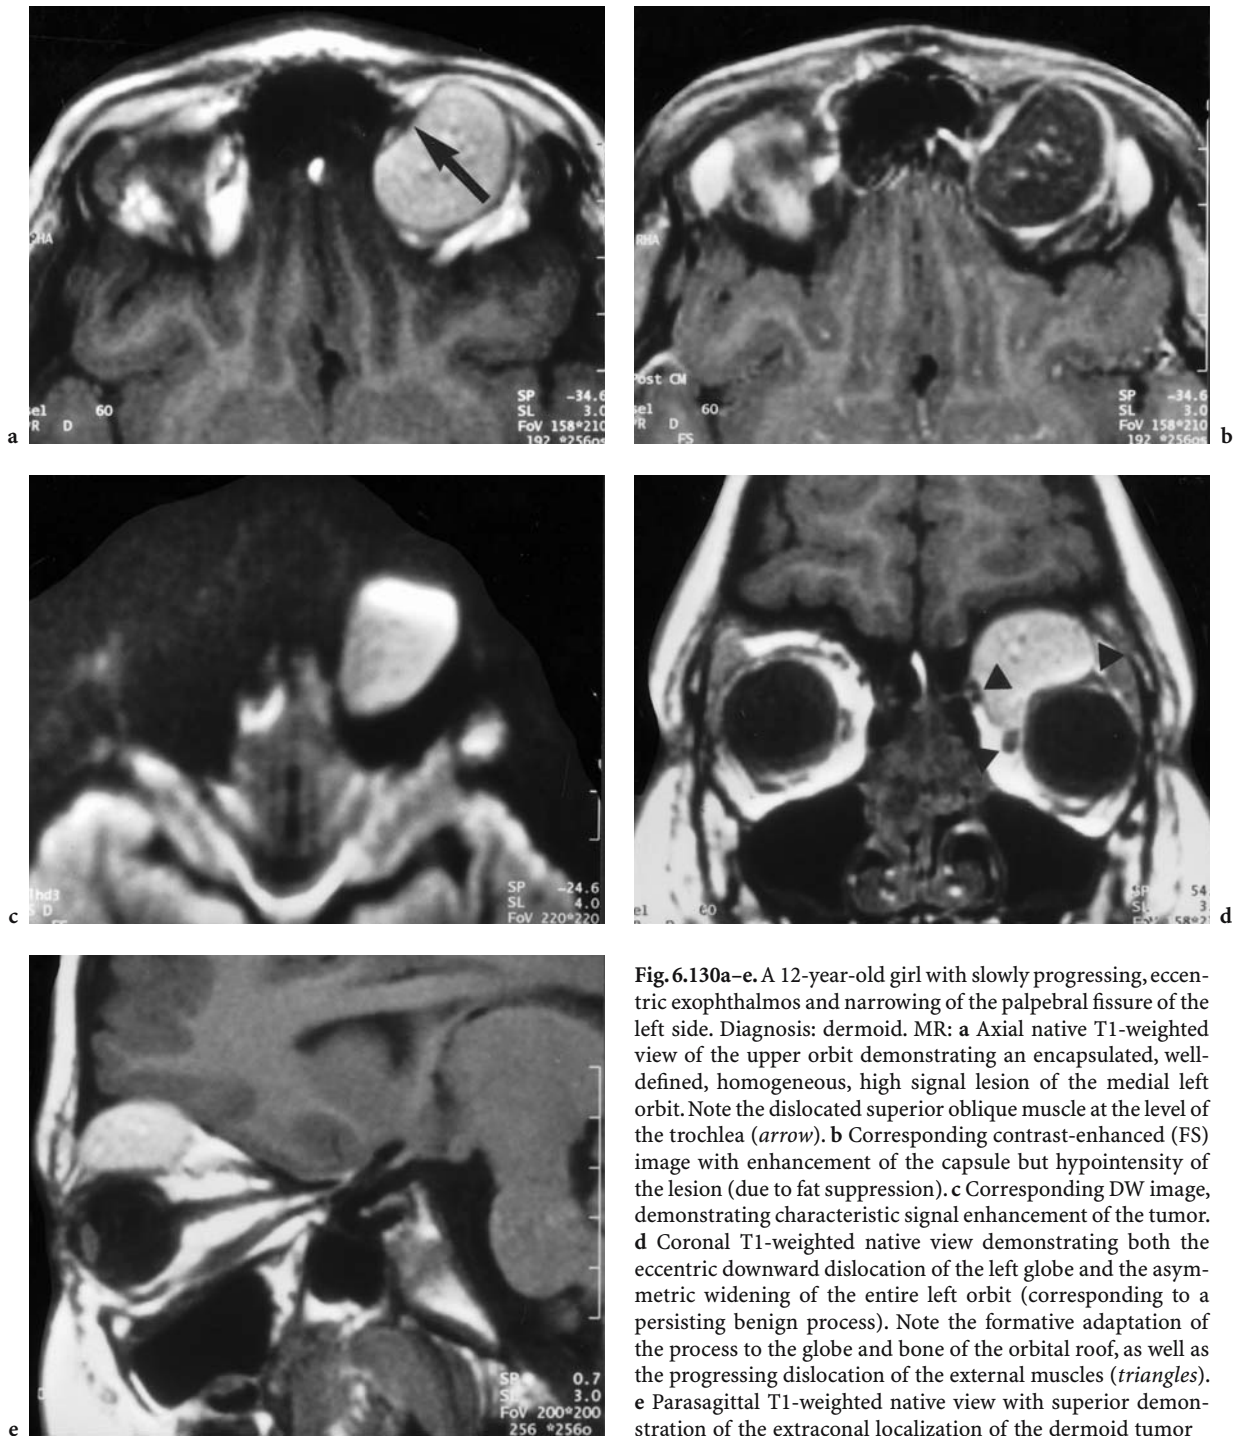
A 12-year-old girl with slowly progressing, eccentric exophthalmos and narrowing of the palpebral fissure of the left side. Diagnosis: dermoid. MR: a Axial native T1-weighted view of the upper orbit demonstrating an encapsulated, well-defined, homogeneous, high signal lesion of the medial left orbit. Note the dislocated superior oblique muscle at the level of the trochlea (*arrow*). b Corresponding contrast-enhanced (FS) image with enhancement of the capsule but hypointensity of the lesion (due to fat suppression). c Corresponding DW image, demonstrating characteristic signal enhancement of the tumor. d Coronal T1-weighted native view demonstrating both the eccentric downward dislocation of the left globe and the asymmetric widening of the entire left orbit (corresponding to a persisting benign process). Note the formative adaptation of the process to the globe and bone of the orbital roof, as well as the progressing dislocation of the external muscles (*triangles*). e Parasagittal T1-weighted native view with superior demonstration of the extraconal localization of the dermoid tumor
